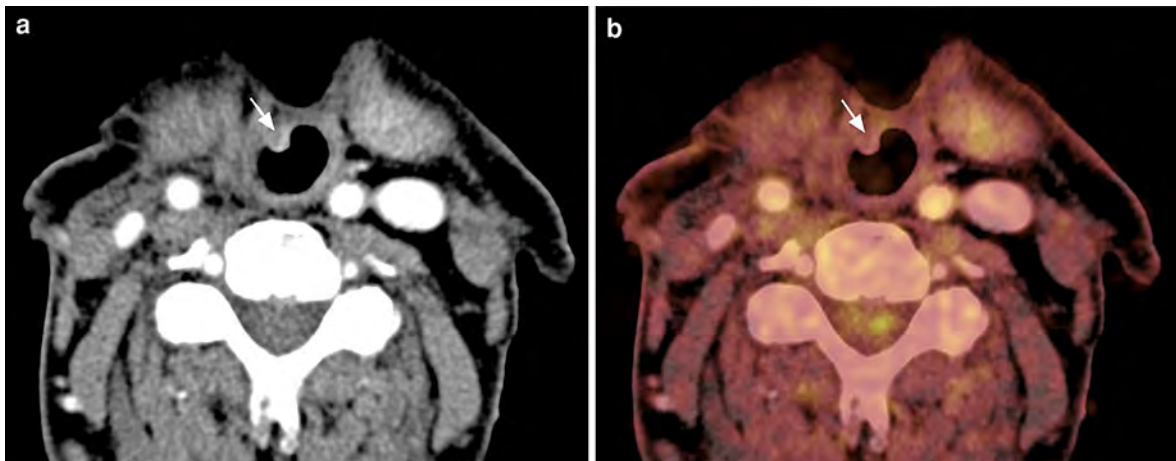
Axial, contrast-enhanced CT (a) in a patient status post total laryngectomy shows a focal polypoid lesion within the neopharynx (arrow in a) that was concerning for recurrent
